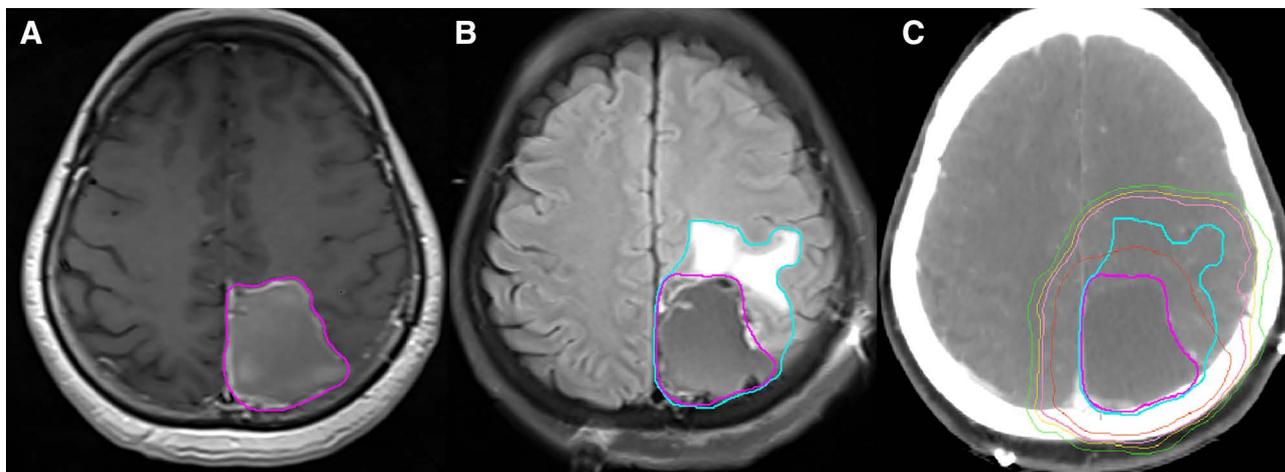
The plan of reduced volume intensity-modulated radiotherapy with simultaneous integrated boost in patients with glioblastoma. (A) Axial enhanced T1 weighted image (B) Axial fluid-attenuated inversion recovery (FLAIR) image (C) RT planning of patients with glioblastoma. Enhanced lesion and resection cavity of enhanced T1 weighted images was contoured as GTV1 (magenta line). High-signal area (peritumoral edema) of T2/FLAIR of magnetic resonance imaging was contoured as GTV2 (cyan line). CTV1/2 were set with 1 cm and 5 mm margins on GTV1 and GTV2, respectively. RT dose was prescribed 60 Gy for PTV1 and 54 Gy for PTV2 (red line-60 Gy isodose curve, pink line-54 Gy isodose curve, yellow line-51 Gy isodose curve, green line-46 Gy isodose curve).
